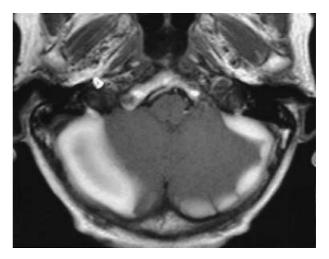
T1-weighted MRI following contrast medium administration depicts the subdural haematomas which are much more pronounced on the right side with compression of the cerebellar hemisphere and of the 4th ventricle
